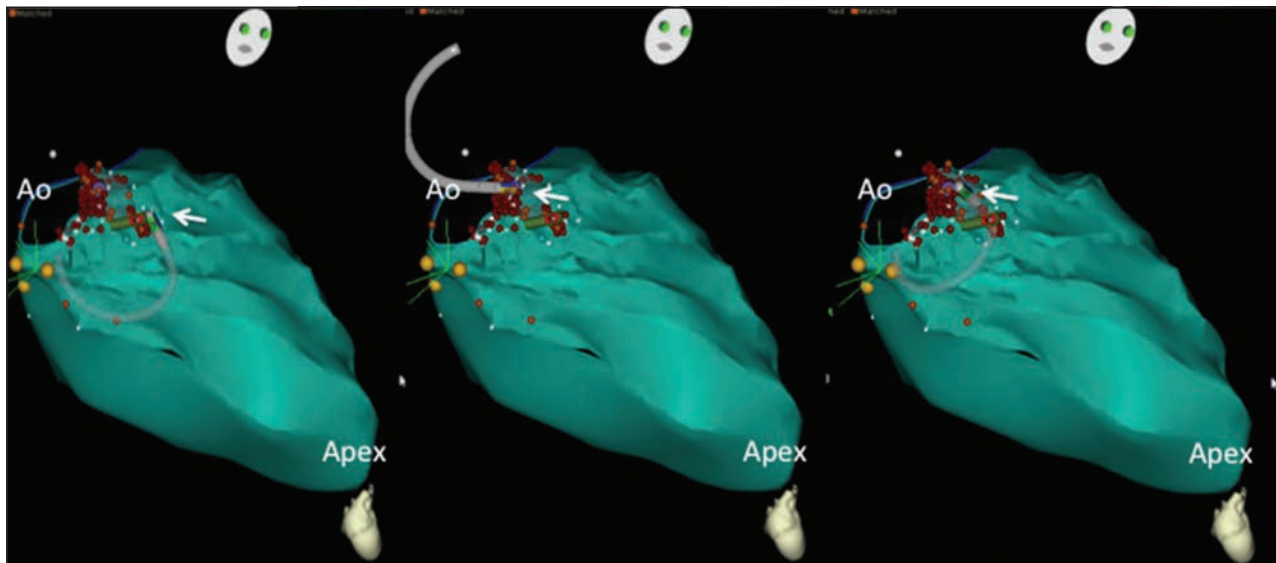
Left panel: 3D reconstruction of echocardiographic contours (green) of the left ventricle from an anterior view showing the aortic (Ao) valve and the left ventricular apex. The catheter location where the PVC was eliminated is shown (arrow). Middle panel: 3D reconstruction of echocardiographic contours (green) of the left ventricle from an anterior view showing the AV and the left ventricular apex. The catheter location where pace mapping was performed (Figure 1-3) is shown. Right panel: 3D reconstruction of echocardiographic contours (green) of the left ventricle from an anterior view showing the AV and the left ventricular apex. The catheter location where pace mapping was performed (Figure 1-3) is shown.
